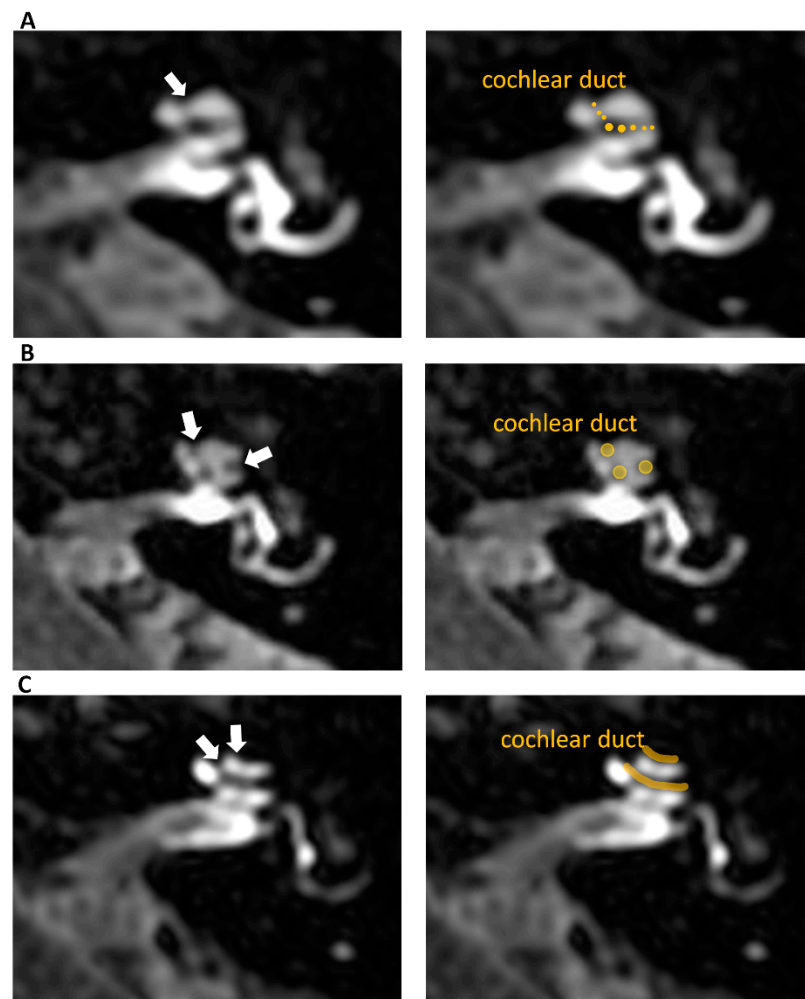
Delayed post-contrast 3D-FLAIR axial images of the left ears at the level of the cochlear modiolus. Right side images on panels (A–C) show the same images as the left ones in respective panels but in the form of companion scans with some line art applied to define specific anatomical structures for easier identification of observed pathologies. Panel (A) presents normal cochlea—grade 0 according to Barath classification, where a non-enhancing cochlear duct is barely visible between the enhancing scala vestibuli and scala tympani (arrow), and no signs of cochlear endolymphatic hydrops are detectable. Panel (B) shows grade 1 cochlear endolymphatic hydrops with partial obstruction of the scala vestibuli by a mildly dilated cochlear duct. The scan shows the nodular non-enhancing regions visible at the margins of the cochlea (arrows). Panel (C) presents grade 2 cochlear endolymphatic hydrops where the cochlear duct is significantly enlarged and obstructs scala vestibuli. The scan shows the non-enhancing stripes within the enhancing scala tympani (arrows).
